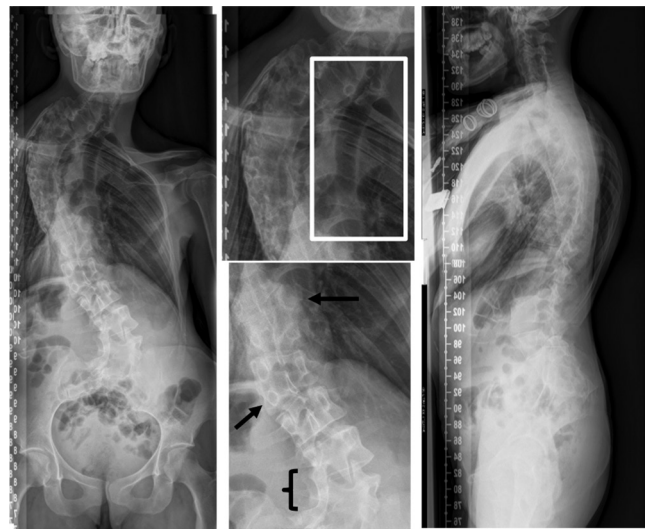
A 34-year-old woman with no comorbidities. Radiographs showed multiple anomalies: T10 right hemivertebra, L1 left hemivertebra, T4-T10 ribs fusions, and L4-L5 left bar. Coronal Cobb angles were T1-T9 73° and L3-L5 54°. Patient-reported outcome measure scores were as follows: Numerical Rating Scale back, 4; Core Outcome Measurement Index back, 3; Oswestry Disability Index, 18%; Scoliosis Research Society 22-item survey (SRS-22) pain, 3.2; SRS-22 self-image, 3.2; and 36-item Short Form Health Survey physical component summary, 42.7. Conservative treatment was indicated.
